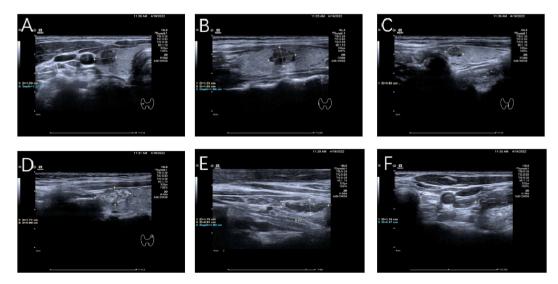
Preoperative ultrasound images of the patient's neck (A), (B) the right thyroid, (C) isthmus of the thyroid gland, (D) the left thyroid, (E) metastatic lymph nodes in the right neck region IV, and (F) metastatic lymph nodes at the angle of the internal jugular vein in level IV of the left neck of this patient.
